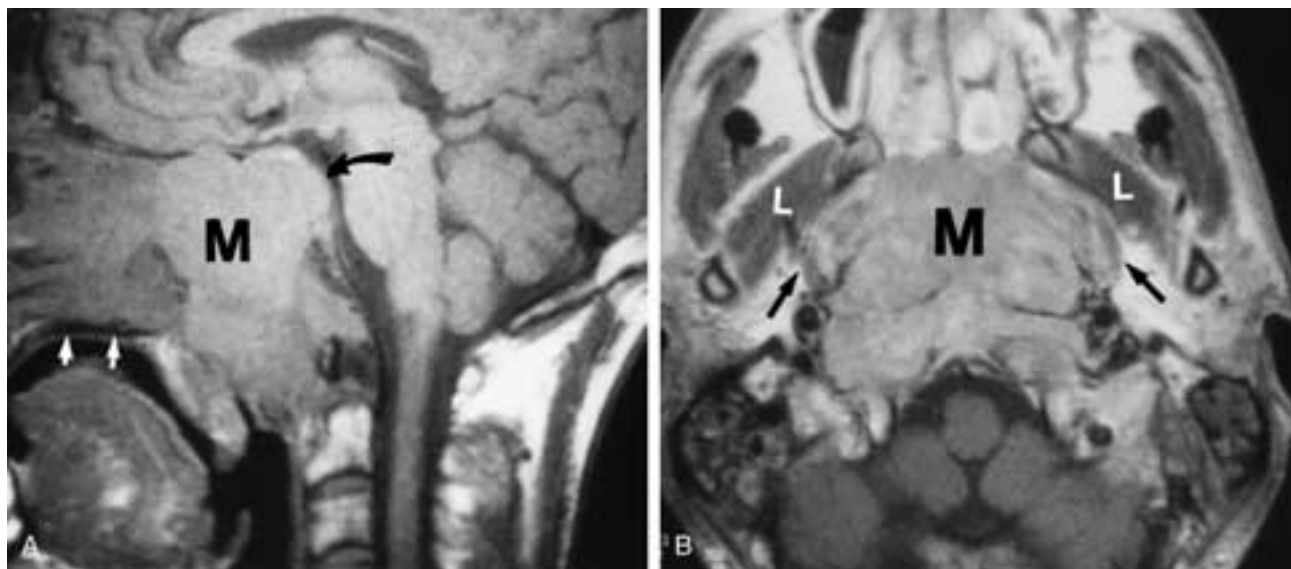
Nasopharyngeal carcinoma. A, Noncontrast sagittal T1-weighted image shows an aggressive soft-tissue mass (*M*) arising in the nasopharynx that erodes the clivus (*curved arrow*). The mass extends inferiorly below the level of the hard palate (*straight arrows*). B, Axial T1-weighted, contrast-enhanced study shows extension of the mass (*M*) into the superior aspect of the parapharyngeal space bilaterally (*arrows*). Note the lateral displacement of the lateral pterygoid muscles (*L*).
